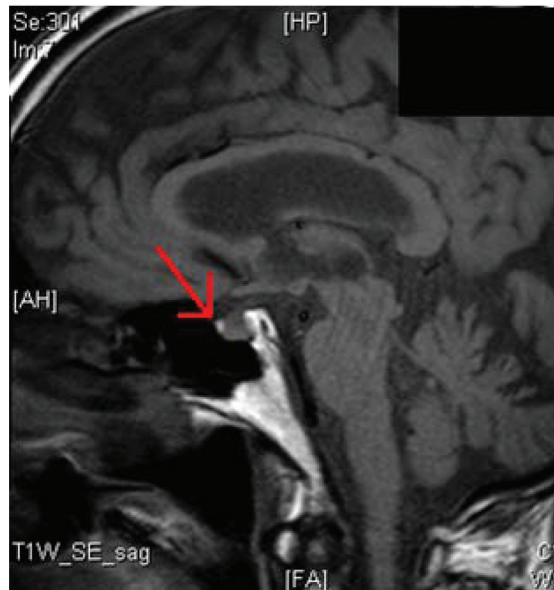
MRI pituitary suggestive of anterior pituitary haemorrhage.
